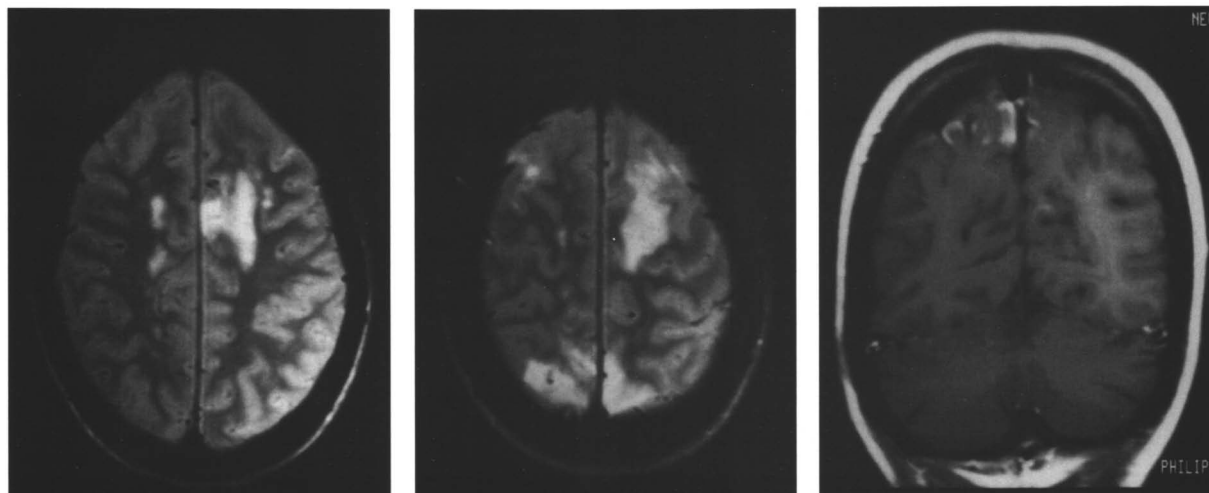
T₂-weighted axial magnetic resonance images in Patient 2. Patchy hyperdensities are present in both occipital lobes and in the precentral and frontal subcortical white matter. Additionally, right paracentral white matter hyperdensities are present (*left and middle panels*). T₁-weighted coronal sections show gadolinium enhancement along cortical gyri and sulci in the occipital paracentral cortex. Slight contrast enhancement of the left calcarine cortex is also present (*right panel*).
